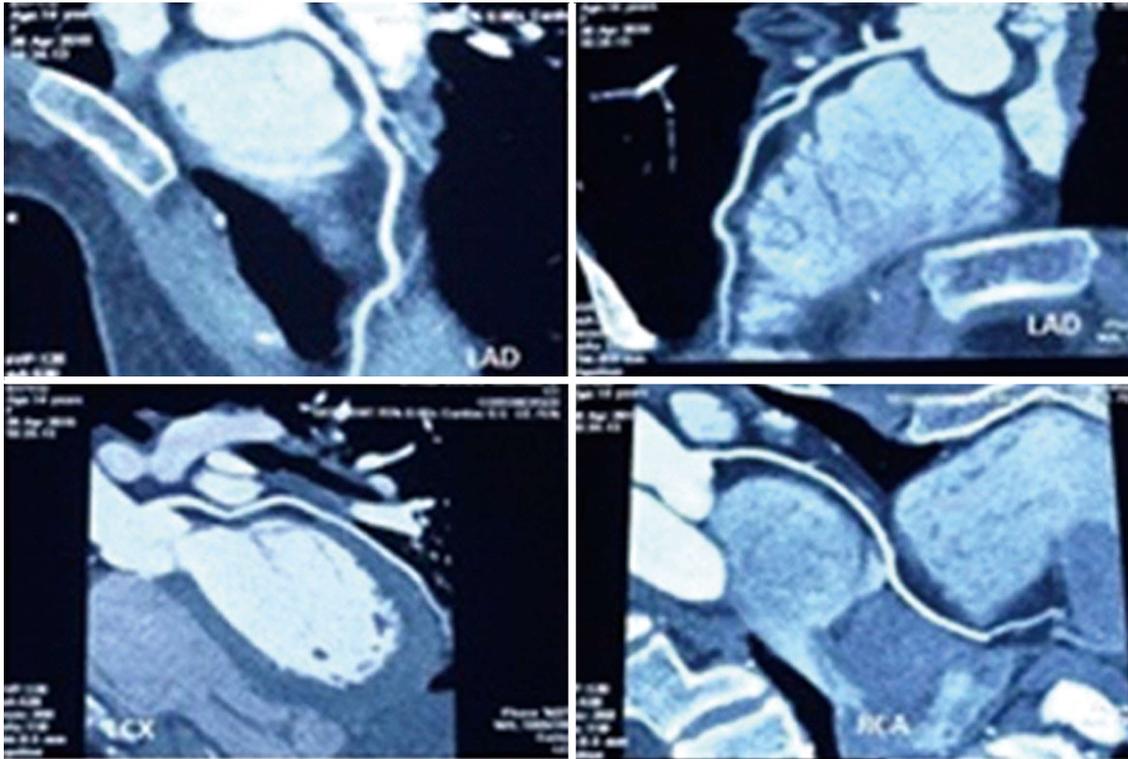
Normal computed tomography angiogram excluding thrombosis.
